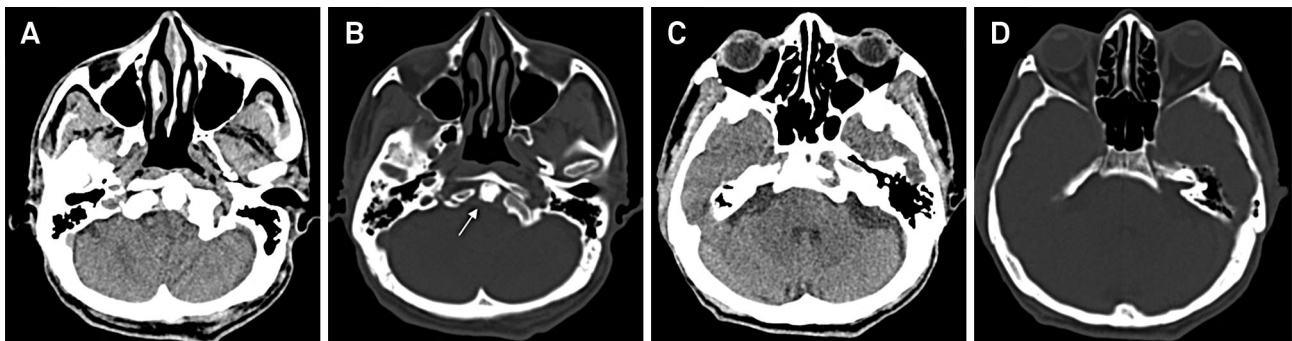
(A-D) Noncontrast cranial CT axial slices showing a higher position of the odontoid (white arrow).
